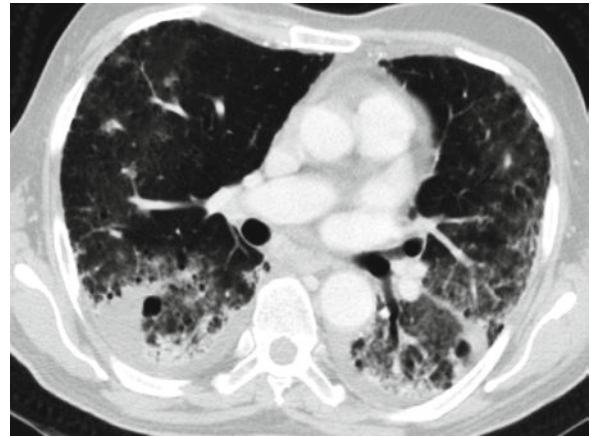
Contrast-enhanced chest CT scan. Progression of the sub-pleural areas of intraalveolar consolidation, “ground-glass” opacities, small pulmonary cysts and thickening of the interlobular septa
